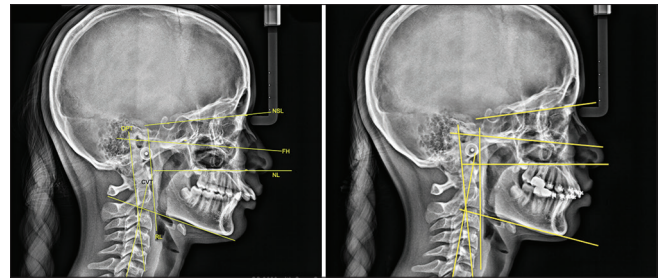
Pre- and post-cephalometric radiographs of a patient treated with FFRD
